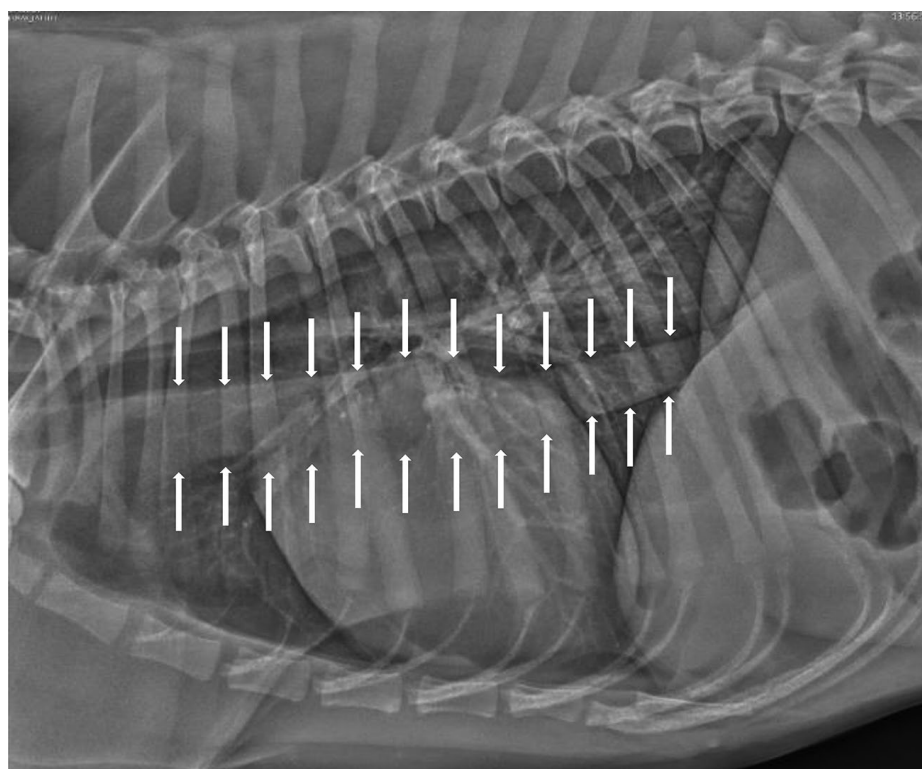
Radiograph of a 9 month old cross breed with unconfirmed AMG. The radiograph confirmed megaesophagus.
